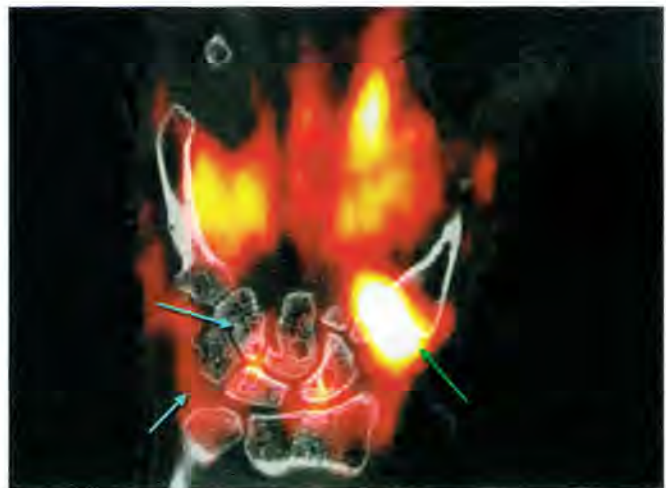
^{18}F -FDG high-resolution extremity PET/CT. Follow-up high-resolution PET/CT 5 weeks after initiation of TNF- α inhibitor therapy.
